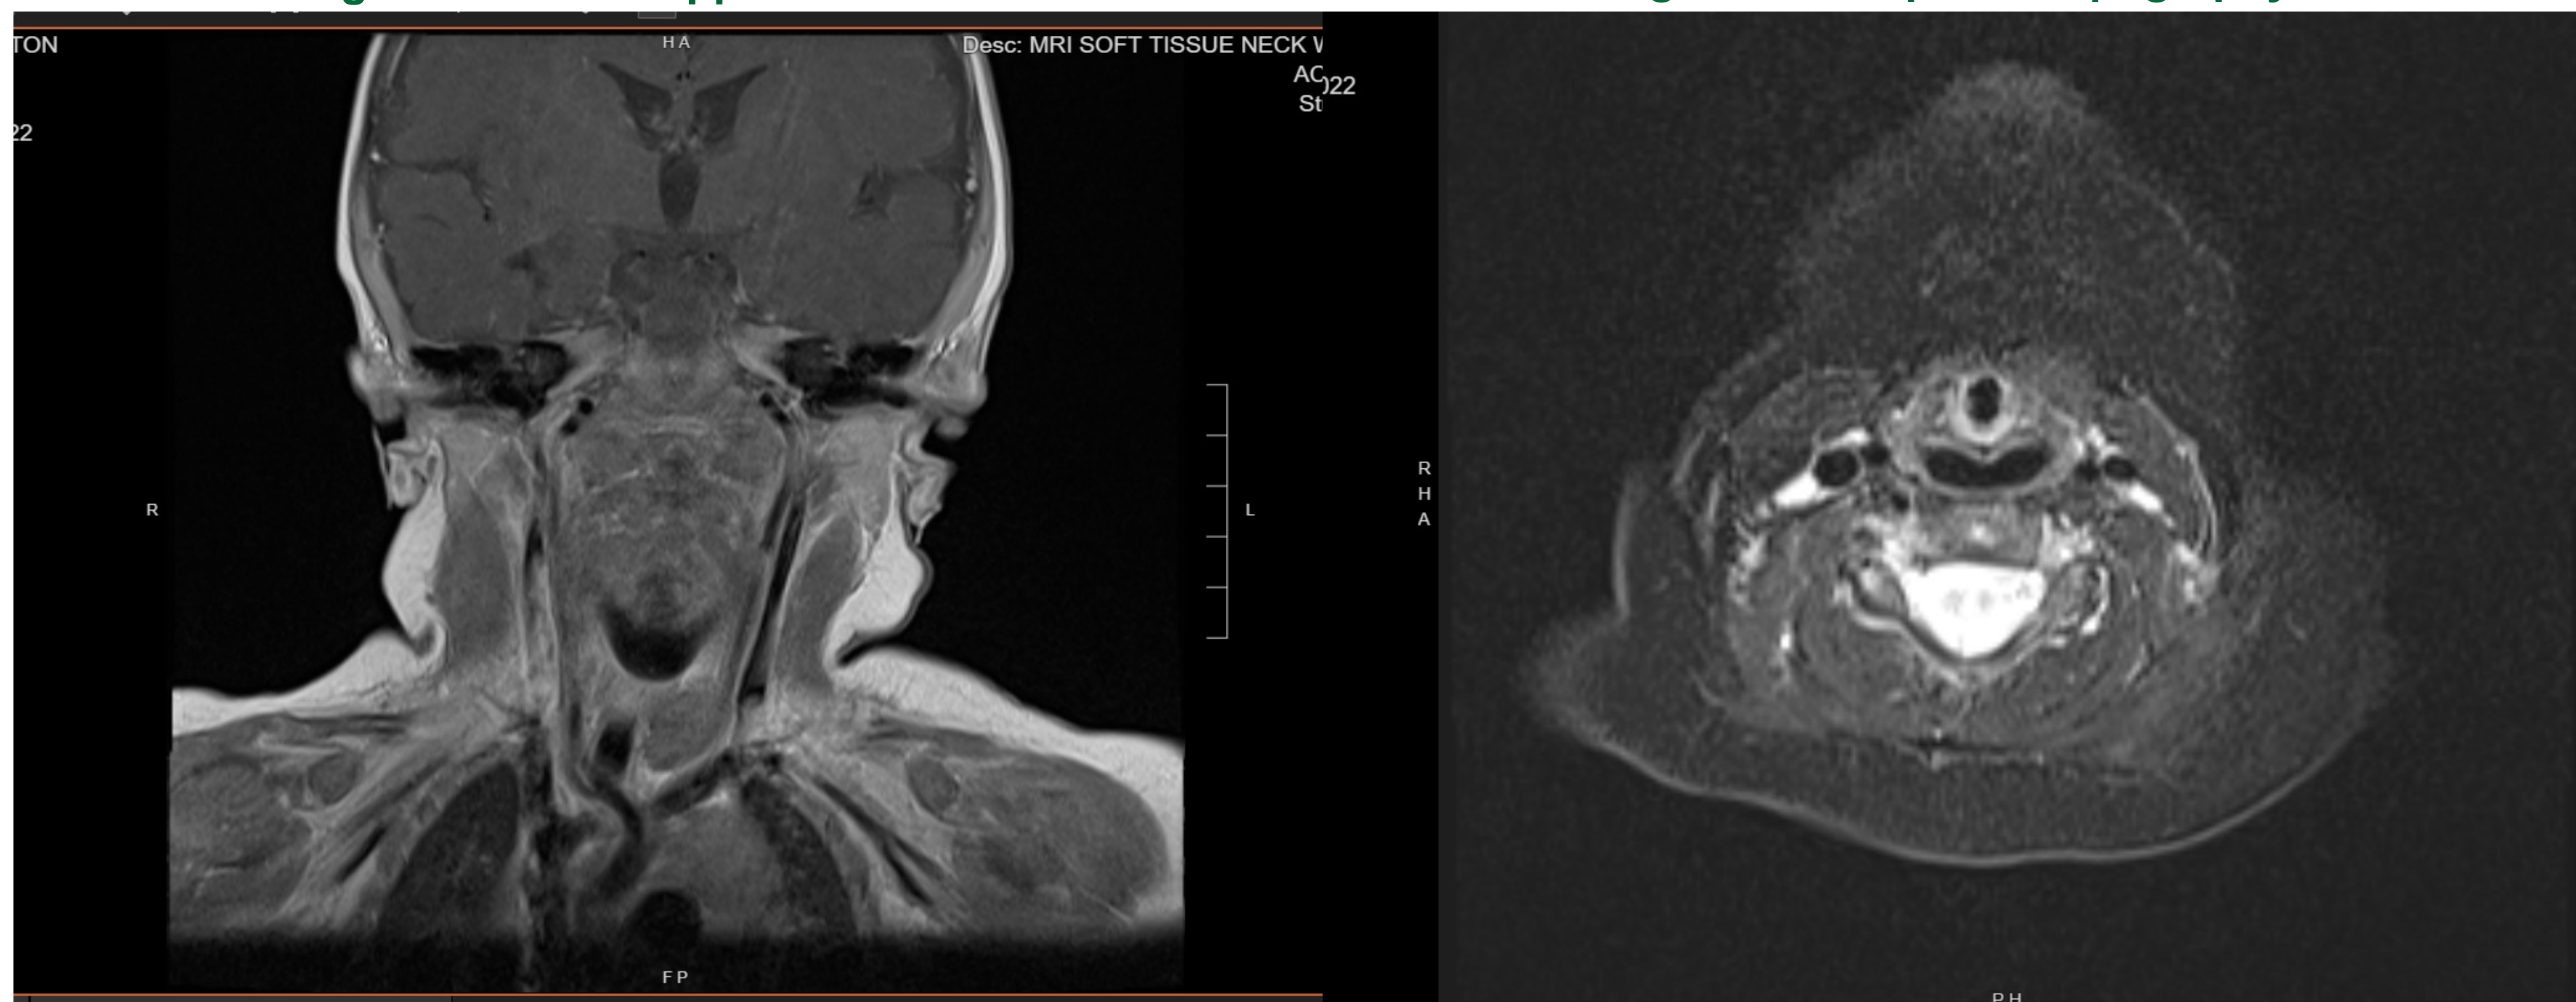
MRI Soft Tissue of the Neck
